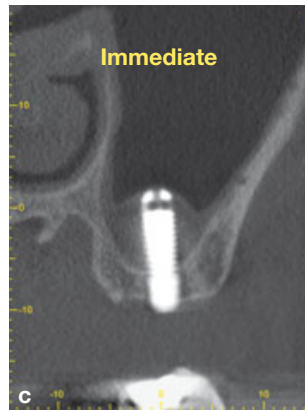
CBCT (coronal view) of the same patient immediately following the procedure.
